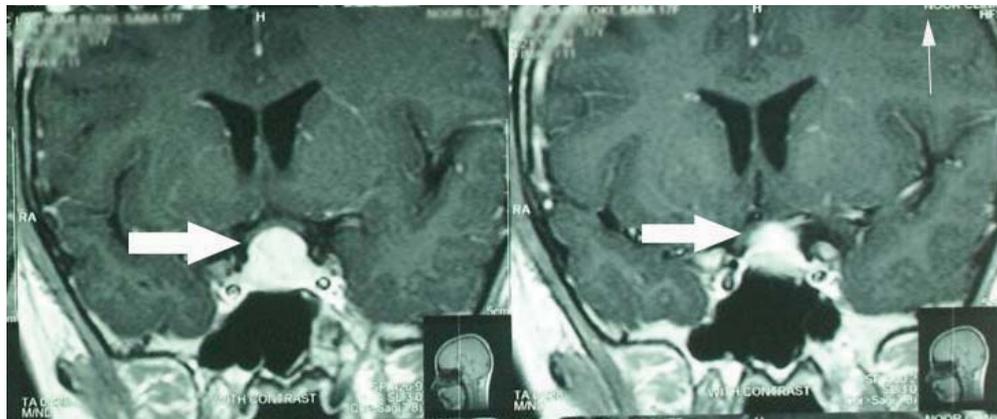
Coronal view of brain MRI with contrast showing the thickening of the stalk and pituitary mass which compressed optic chiasma.
